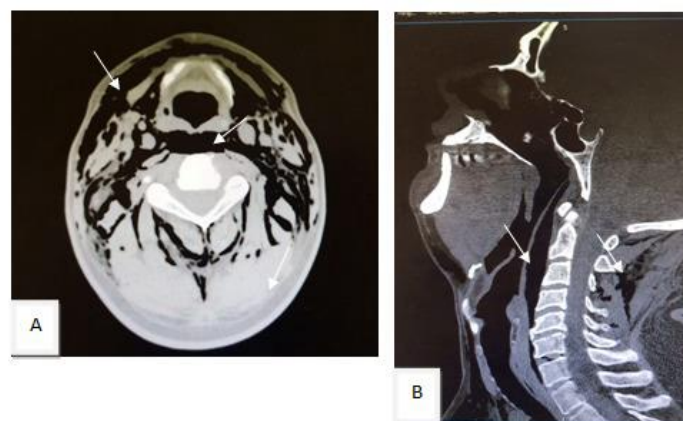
Axial (A) and Sagittal (B) CT scan for the neck, showed: Extensive emphysema tracks along the superficial and deep layers of neck soft tissues (white arrow)
